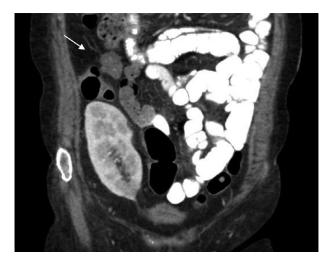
Coronal CT with IV and oral contrast from late 2020 after the resolution of the patient's ascending colitis shows her pelvic transplant kidney and biopsy proven RLQ lymphoma mass (white arrow [3.1cm]) radiologically stable from prior imaging with no evidence of an additional pelvic mass.
